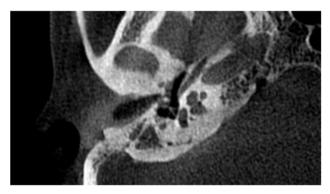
(b): CBCT axial scan showing the stapes superstructure attached to the oval window.
